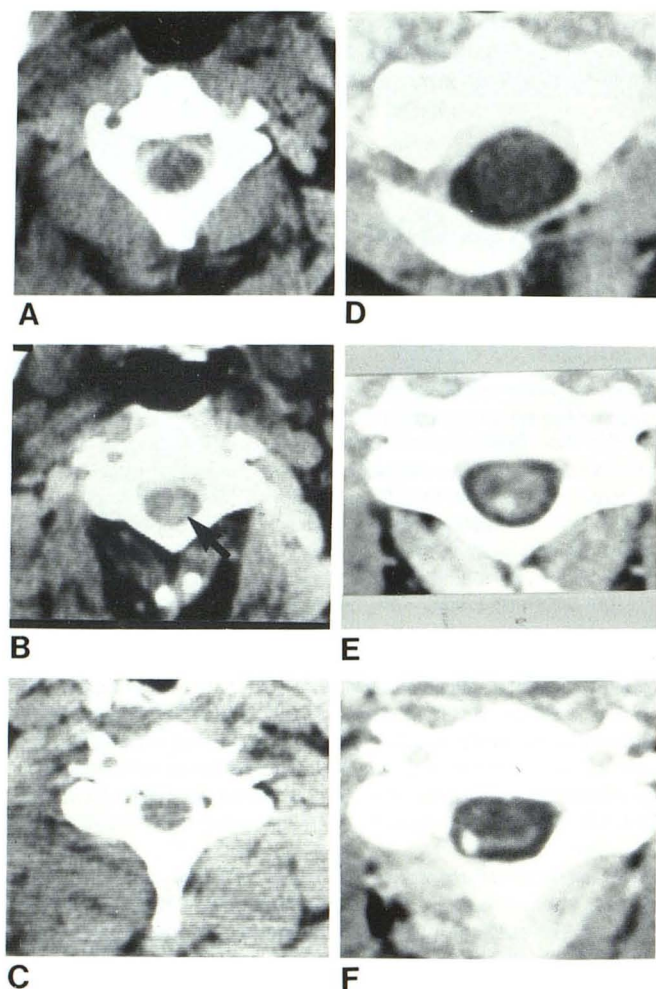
A–C, Spinal CT about 4–5 hr after instillation of metrizamide. Cord enlargement. A, C2 level. B, C4 level. Subtle increase in cord density (arrow) suggests cystic structure within cord. C, C5 level. Cord of near-normal size. D–F, CT after double-dose intravenous contrast enhancement. Inhomogeneous enhancement of cord. D, C2 level. No enhancement. Cord appears to be of low density. E, C4 level. Inhomogeneous contrast enhancement with nodule posteriorly on right. Several low-density regions within cord. F, Similar findings at C5 level, again with large part of cord being of irregular low density, suggesting multiloculated cysts; brightly enhancing tumor nodule was seen posteriorly on right. Heterogeneous tumor suggested by contrast-enhanced CT combined with metrizamide CT appearance suggested possibility of associated cysts.
